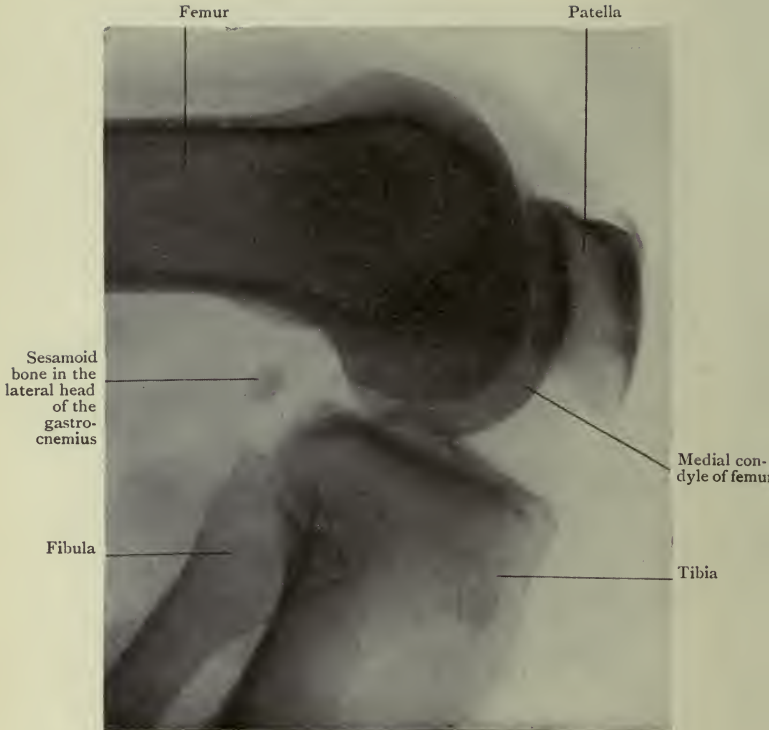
Radiograph of a fully flexed Knee.
